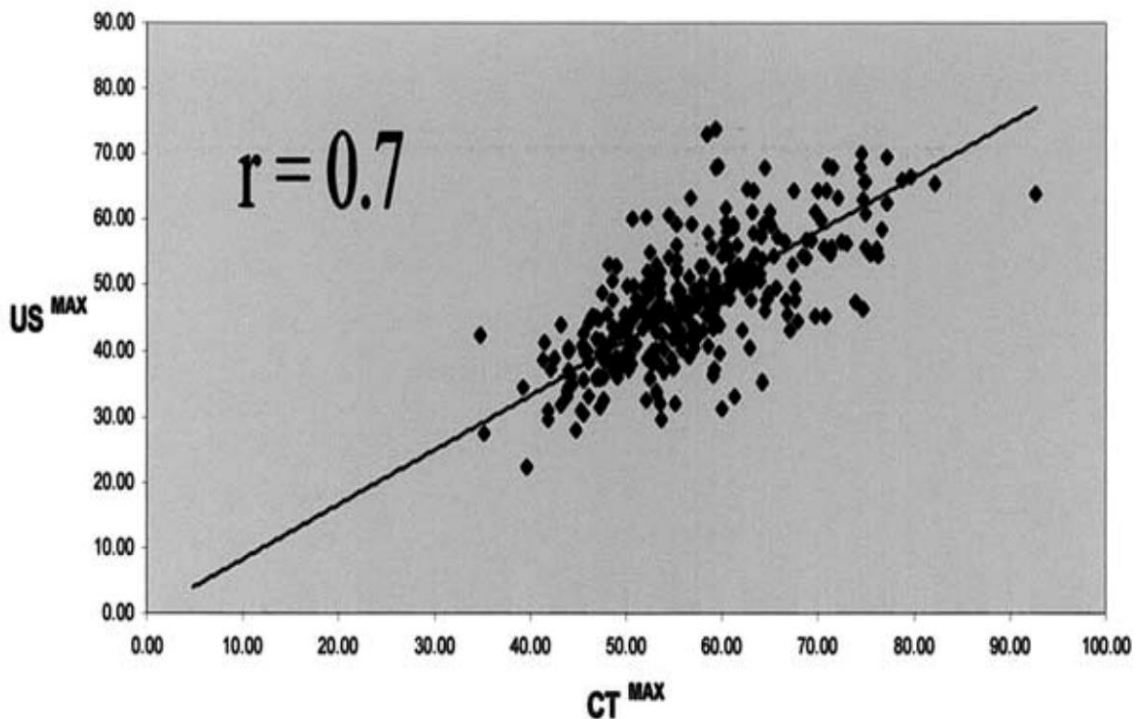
Correlation between CT^{\max} and US^{\max} . Reprinted from J Vasc Surg, 38(3):466-71, Sprouse LR, 2nd, Meier GH, 3rd, Lesar CJ, Demasi RJ, Sood J, Parent FN, et al. Comparison of abdominal aortic aneurysm diameter measurements obtained with ultrasound and computed tomography: Is there a difference? Copyright 2003, with permission from Elsevier.
